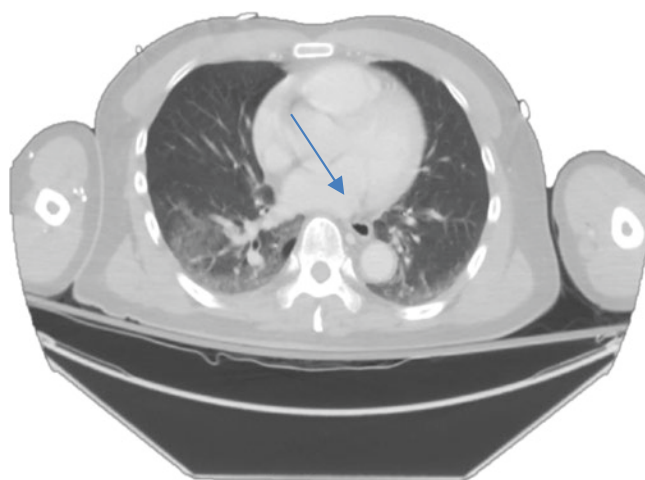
CT image with free air. CT thorax reveals free air in the mediastinum (arrow). Also noted are pulmonary contusions bilaterally posteriorly
